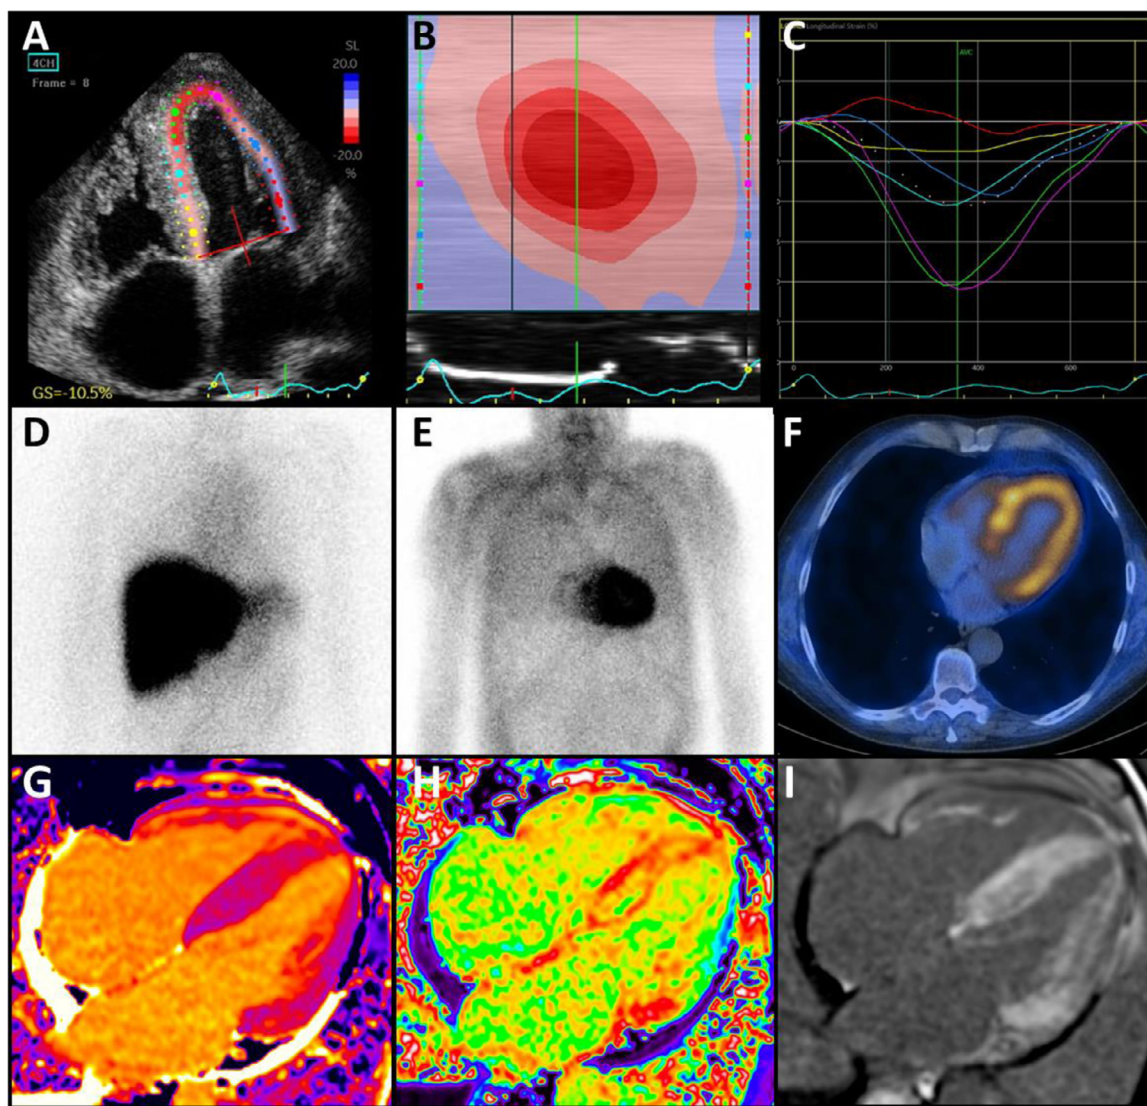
Figure Imaging features of systemic amyloidosis. Echocardiography: (A) 4-chamber view with biventricular hypertrophy, and (B and C) “bullseye” pattern of apical sparing of longitudinal strain and reduced global longitudinal strain. Nuclear medicine imaging: (D) SAP scintigraphy demonstrating liver amyloid deposition, (E) DPD scintigraphy with Perugini grade 3 cardiac uptake, (F) single-photon emission computer tomography (SPECT) demonstrating biventricular cardiac uptake. Cardiac magnetic resonance imaging: (G) diffusely elevated T1 values at 1149 ms, (H) diffusely elevated extracellular volume of 63%, and (I) diffuse transmurular late gadolinium enhancement. DPD = 3,3-diphosphono-1,2-propanodicarboxylic acid; SAP = serum amyloid P.
